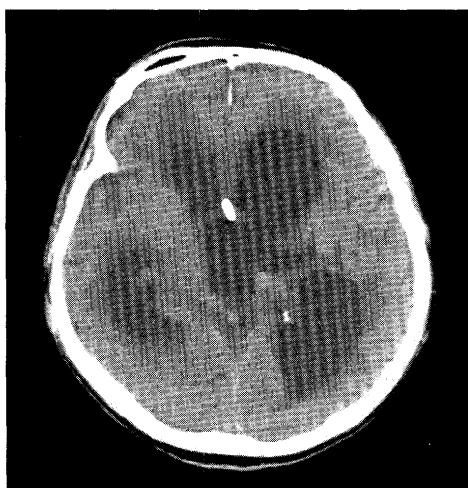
CT demonstrating hydrocephalus. Normalization of the ventricle size couldn't be achieved even after V-P shunt revision. The patient was admitted in a stuporous condition to our hospital after V-P shunt surgery secondary to left thalamic hemorrhage. The ventricle size was very large with peri ventricular lucency; however, it did not show any change even after V-P shunt revision
